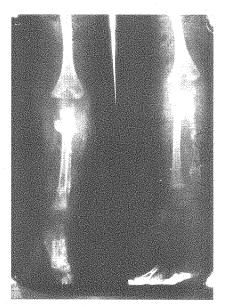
X-ray plate exhibiting erosion of whole ulnar shaft.
